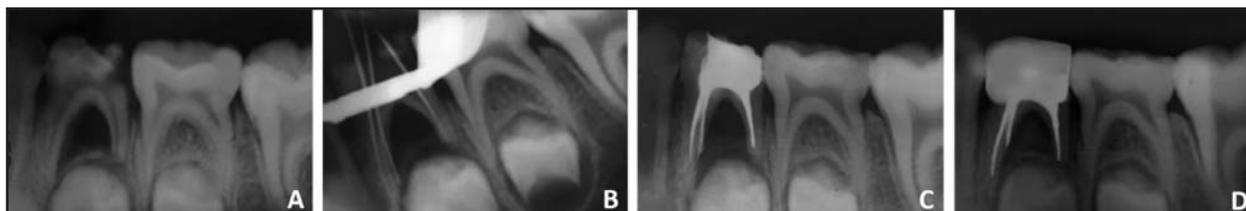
Successful pulpectomy in a lower left first molar. A: Initial image: carious lesion involving pulp and interradicular radiolucency. B: Determination of working length. C: Immediately postoperative image. D: X-ray. 12 months postoperative.
